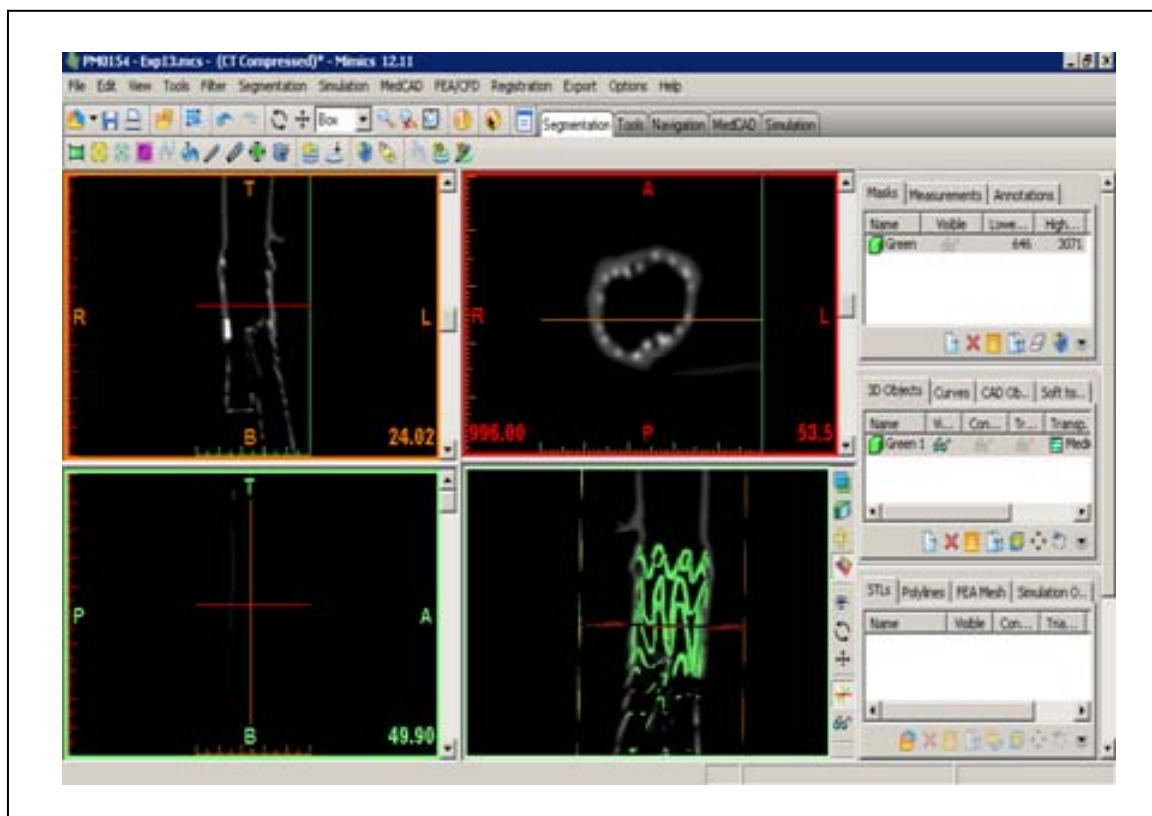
Syngo CT scanner software visualization of stent graft. Syngo allows for rotation and oblique slicing of EVG for better evaluation (left). Mimics software allowing for volume rendering and visualization of image slices (right).
